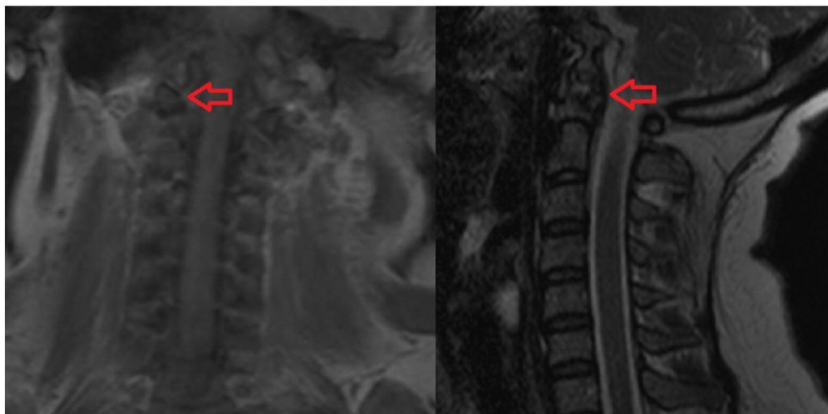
T1-weighted MRI of the patient demonstrating the OCF.
